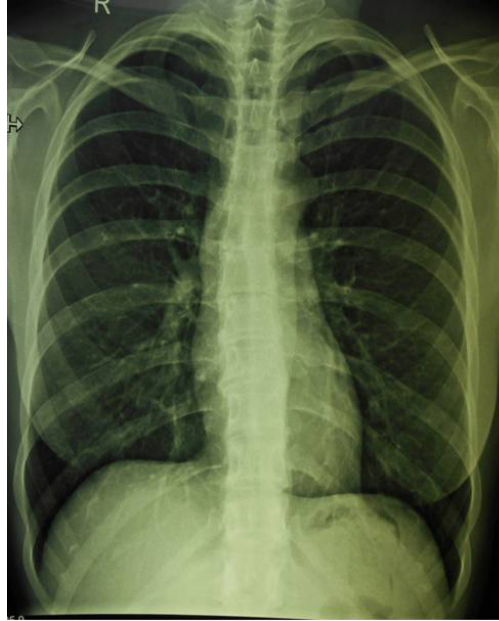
Chest radiograph shows normal cardiac silhouette, with slightly bulged right upper arch (dilated ascending aorta) and also dilated descending aorta. Hyperdensity can be observed in some lower borders of ribs.
